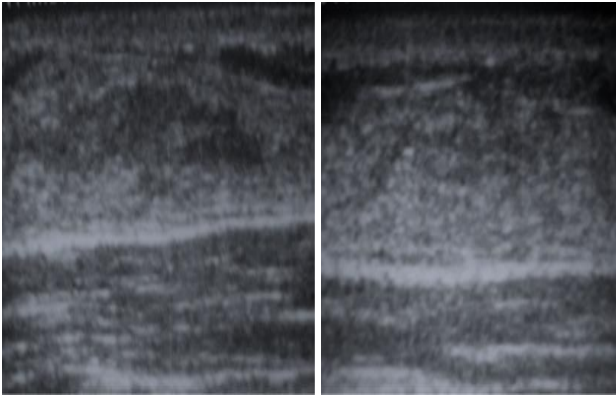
Bilateral mixt type gynecomastia on the breast sonography of the same patient.
